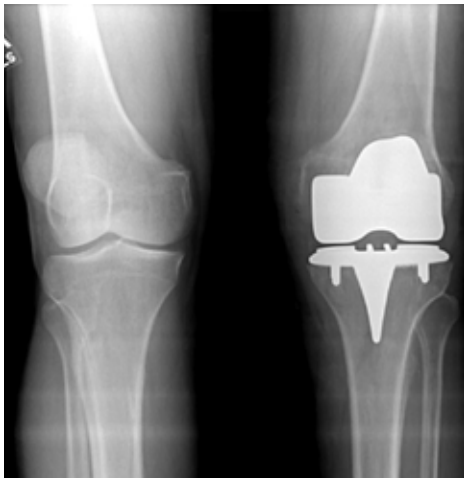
Preoperative standing AP radiograph of left TKA. Aspiration cultures grew *Staphylococcus warneri* and *Stenotrophomonas maltophilia*.
